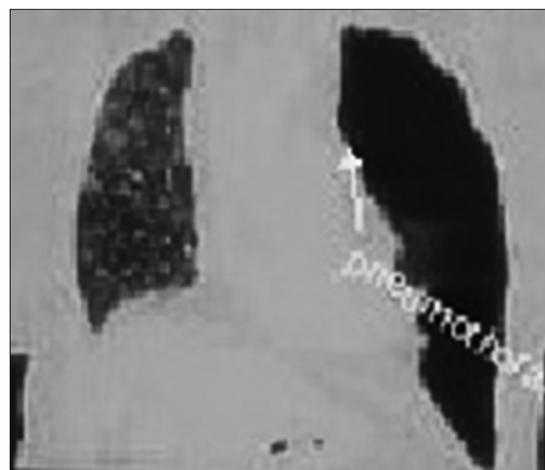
High-resolution computed tomography chest - white arrows showing large pneumothorax on the left side
